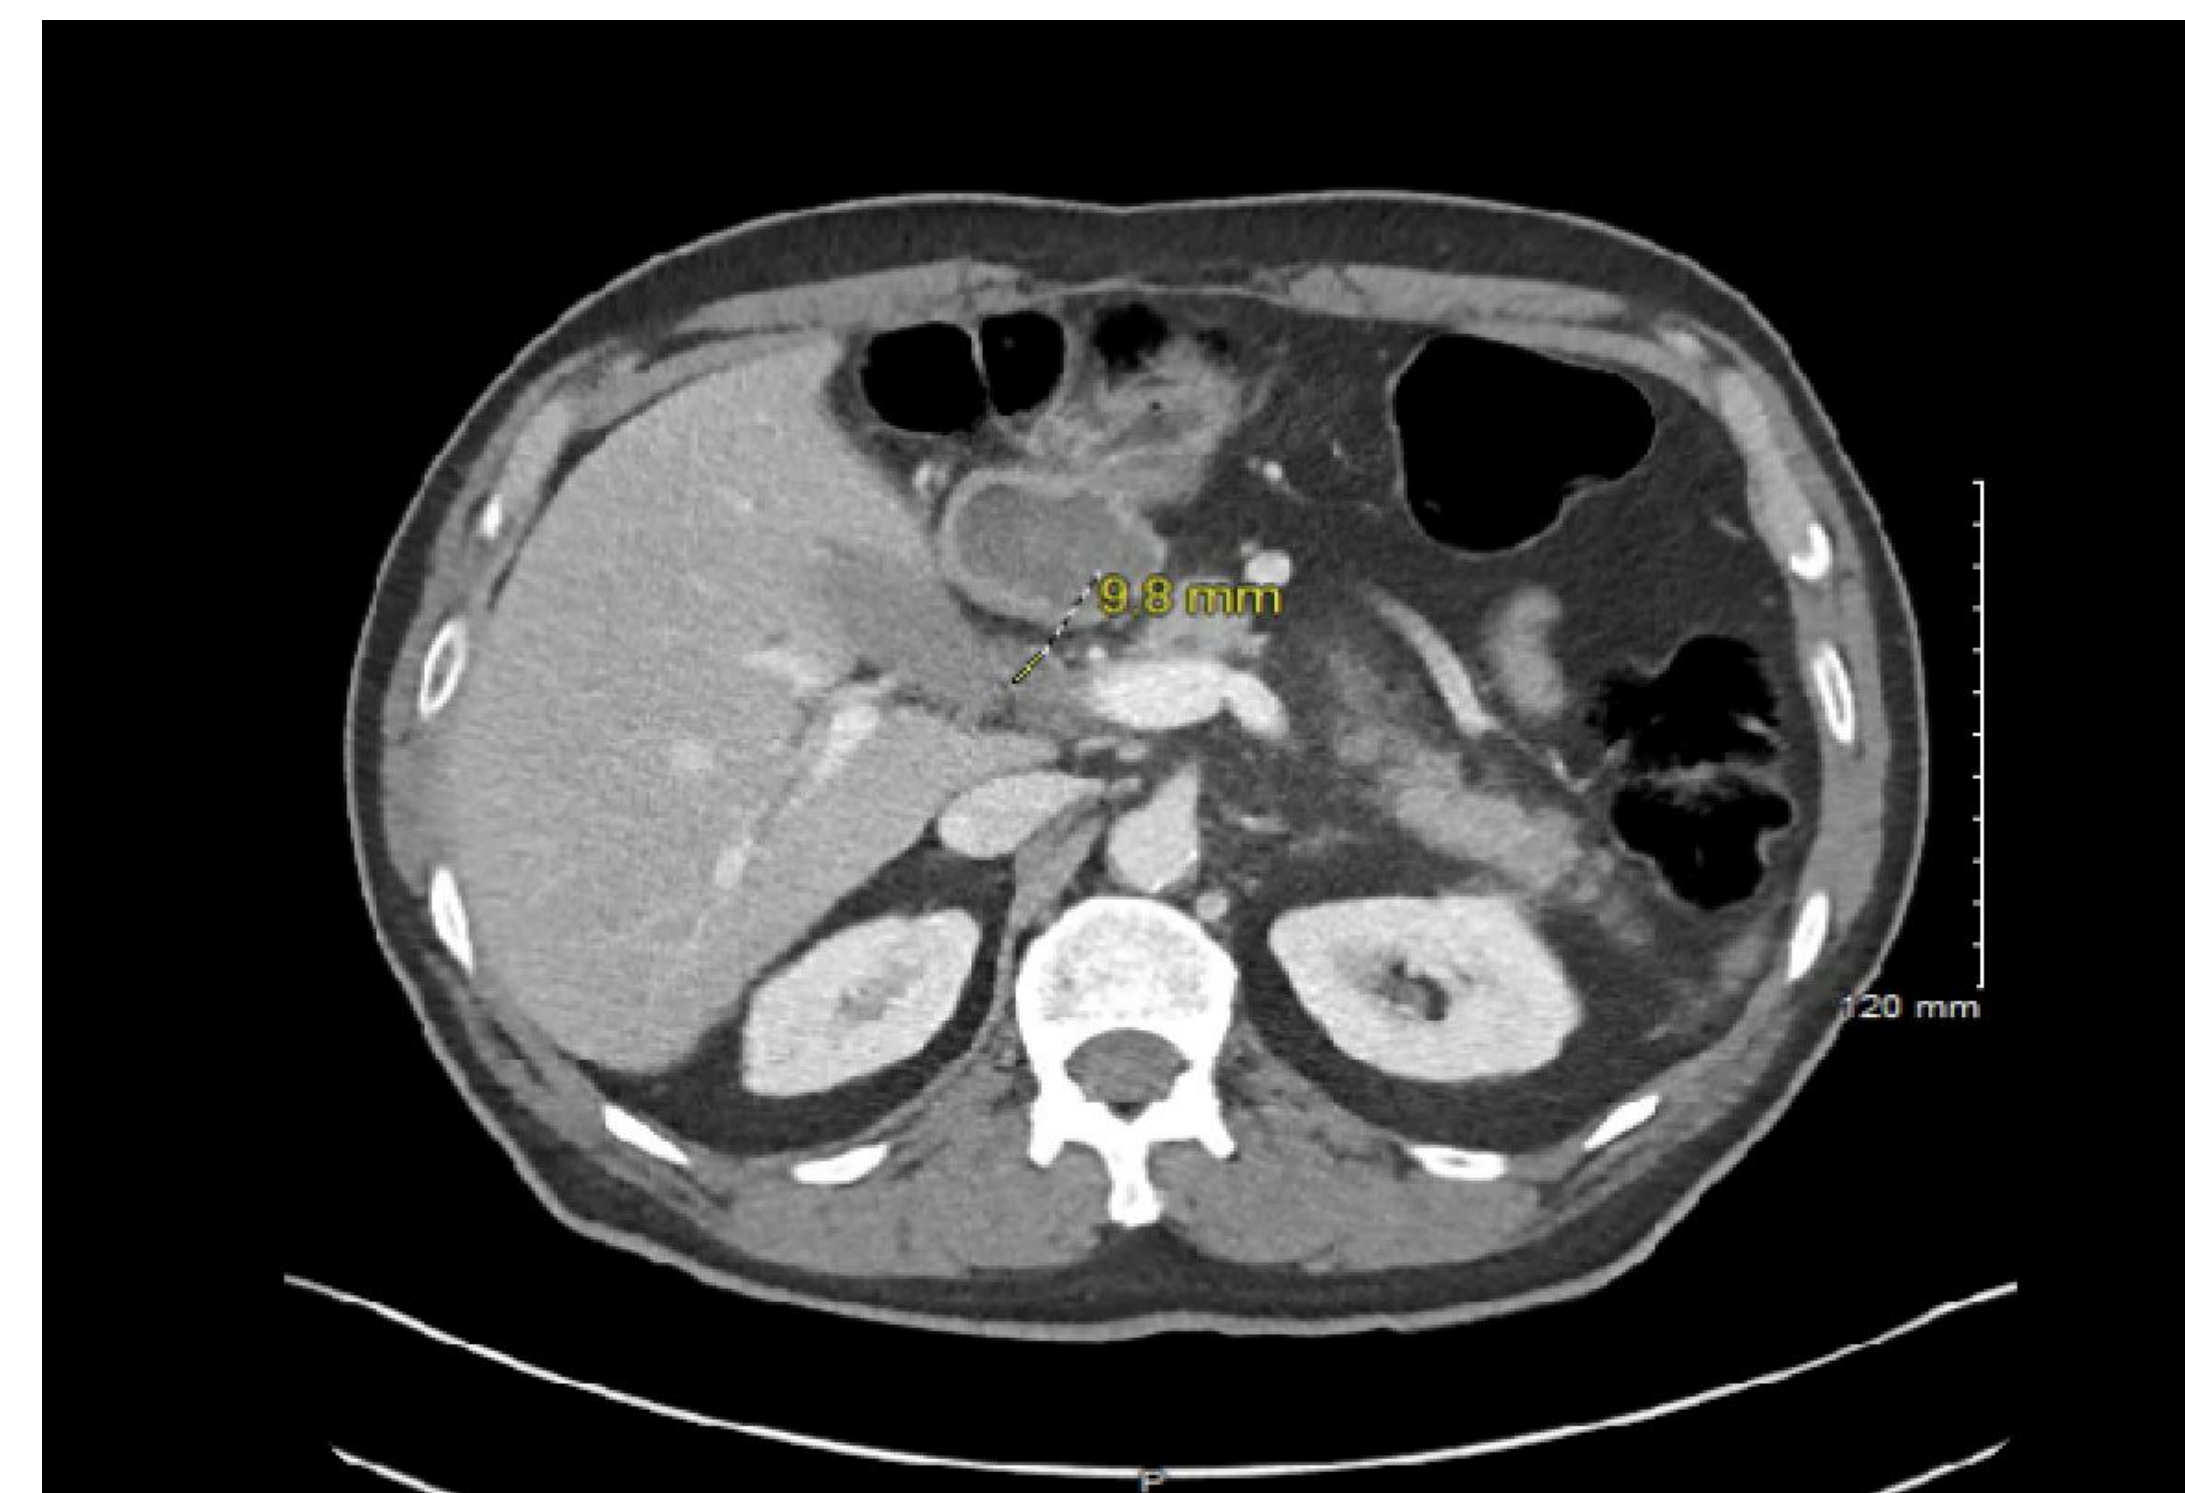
CT of the abdomen show pancreatic mass and bile duct dilatation
